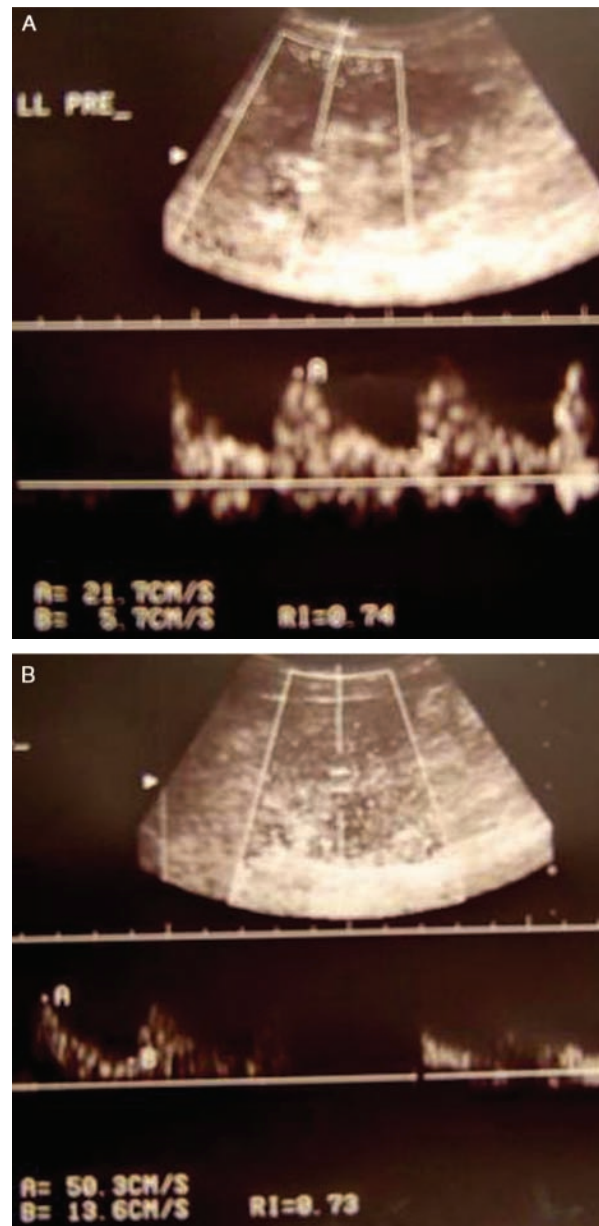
Spectral Doppler sonographic examination evaluating left kidney with grade V vesicoureteral reflux, (A) prior to and (B) after voiding cystoureterography. Renal resistivity index is increased, with no marked difference after voiding cystoureterography.
